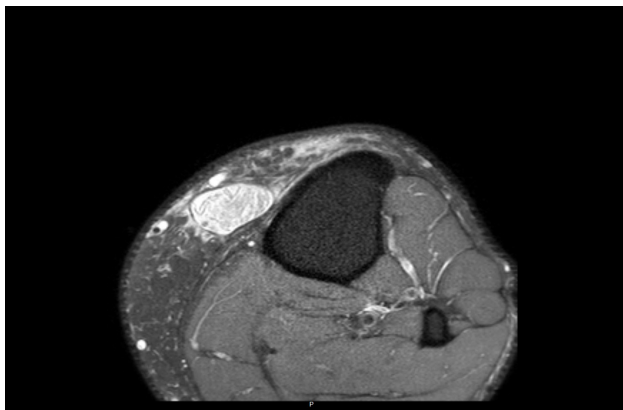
Coronal plane T1-weighted MRI image at 6 months after initial trauma showing a now encapsulated subcutaneous fluid collection confirming the diagnosis of a Morel-Lavallée lesion (partial lysis of the haematoma).
